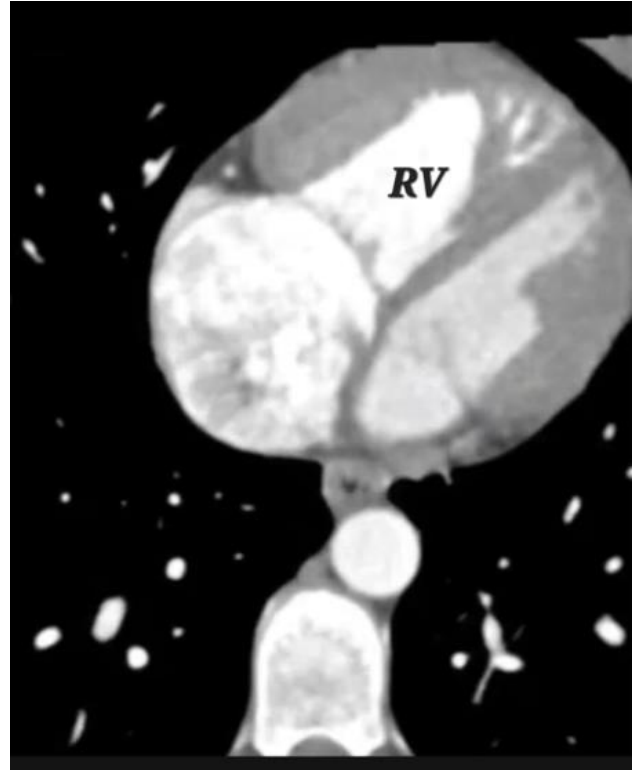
CT angiography showing mildly enlarged RV with thickened wall, suggestive of RV hypertrophy (reprinted with permission of the patient)
